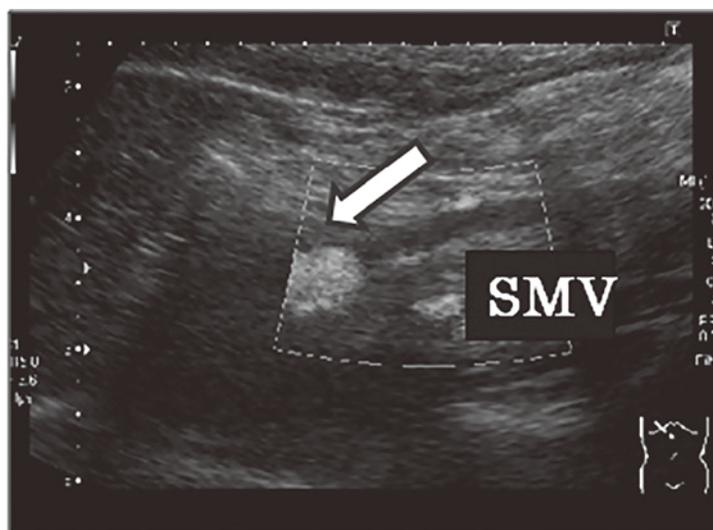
Ultrasonography revealed extensive thrombosis in the superior mesenteric vein (SMV) (arrow) without edematous change of the small intestine.
